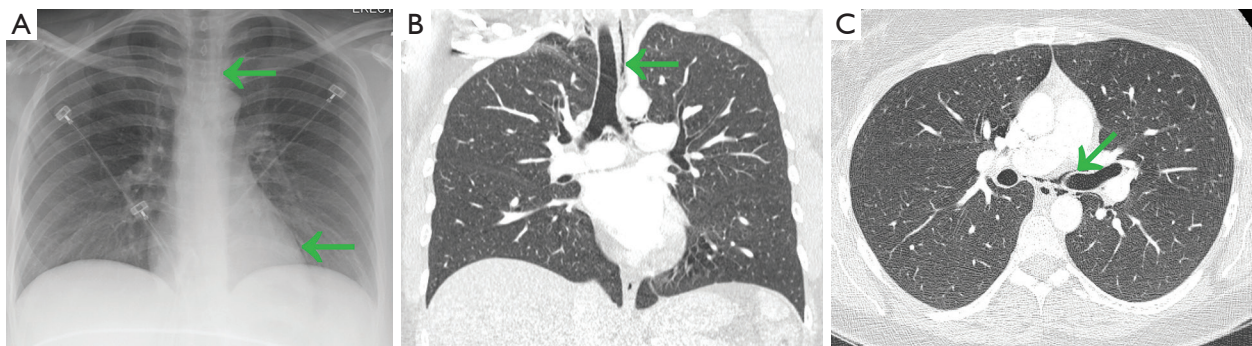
Subtle pneumomediastinum identified on CXR after review of CT imaging. (A) CXR demonstrating initially unrecognized pneumomediastinum. Arrows indicate pneumomediastinum gas identified retrospectively. (B) Representative axial view from CT chest of the same patient. Pneumomediastinum is indicated by arrow. (C) Representative coronal view from CT chest of the same patient. Arrow indicates pneumomediastinum. CXR, chest radiograph; CT, computed tomography.
